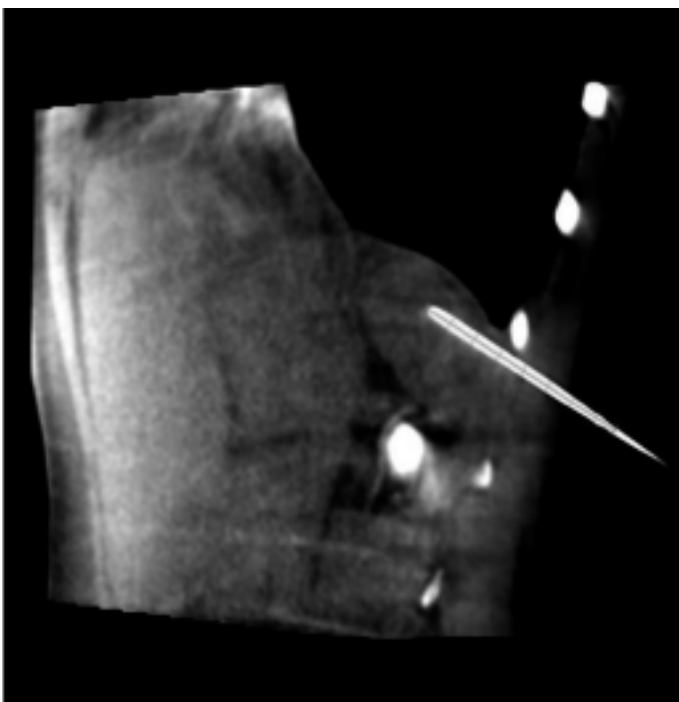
Control cone-beam CT
